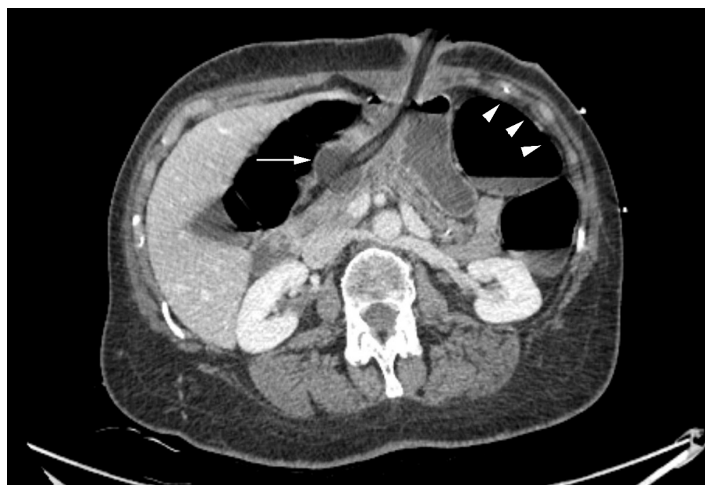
Computed tomography of the abdomen and pelvis, axial view, demonstrating the Foley catheter with balloon in the gastric antrum (arrow), with resulting gastric outlet obstruction and colonic distension (arrowheads).
